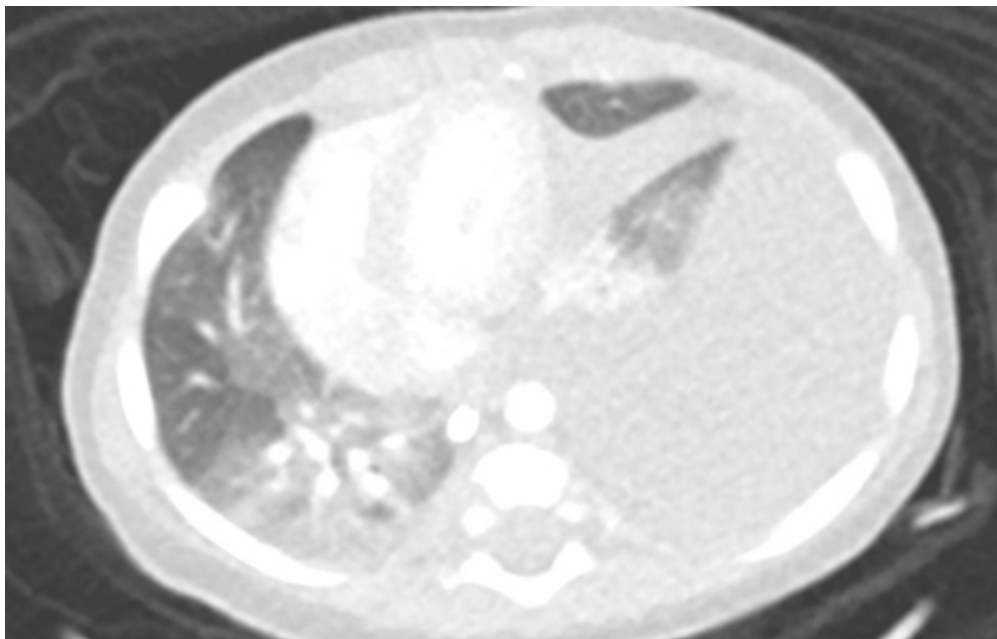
CT thorax showing the large pleural effusion, partly collapsed left lung and marked mediastinal shift to the right. There was no intrathoracic mass found. ↩
